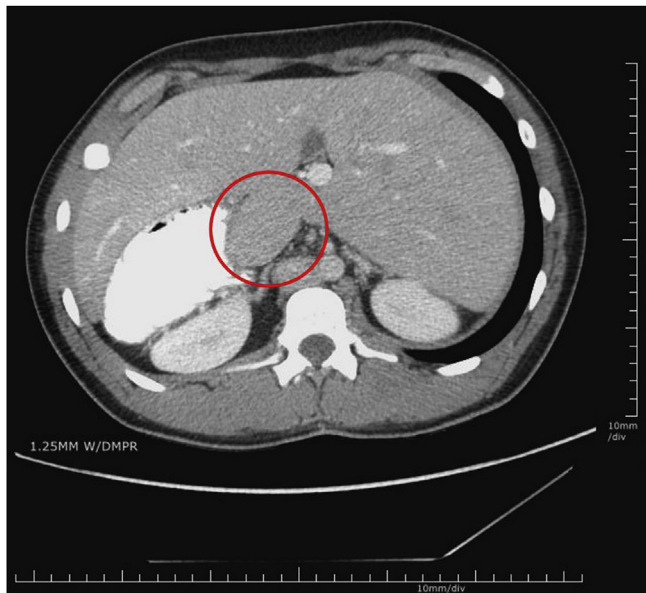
Abdominal CT, axial view, showing polysplenia with a spleen circled in red.
